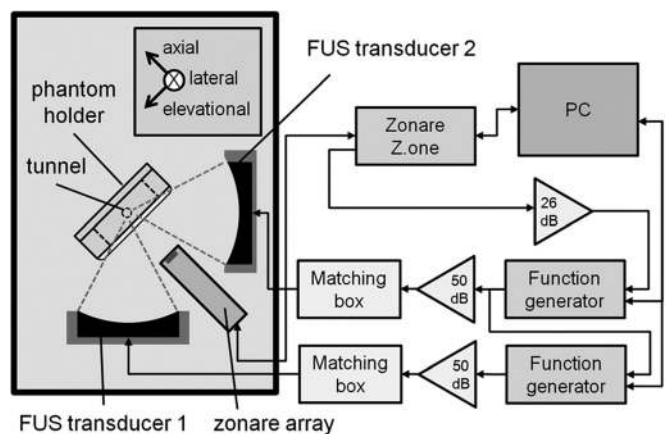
Overview of experimental apparatus. Two focused ultrasound transducers, the foci of which perpendicularly overlapped, generated therapeutic ultrasound, aimed at a vessel embedded within a tissue mimicking material through which contrast agent suspensions could be made to flow. Each transducer was driven at 500 kHz by a function generator through a 50 dB power amplifier and matching network. A diagnostic linear array (L10-5, Zonare, Zonare), which was placed 36.5 mm from the focal point, was used to acquire B-mode images before sonication and to passively receive acoustic emissions over 64 independent channels during sonication. The Z.one engine was used to digitize and store channel data as well as to trigger the function generators.
